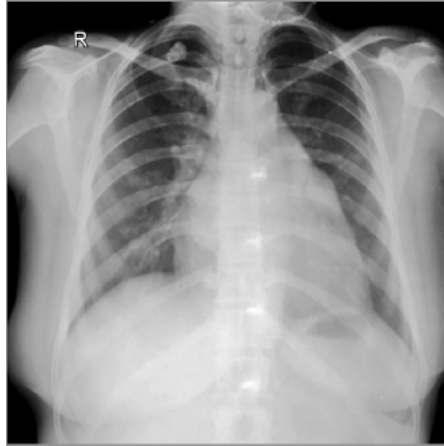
Chest X-ray PA view showing gross cardiomegaly with stenciled heart borders, lungs clear. Suggestive of pericardial effusion. Differential diagnosis—Ebstein's anomaly.
